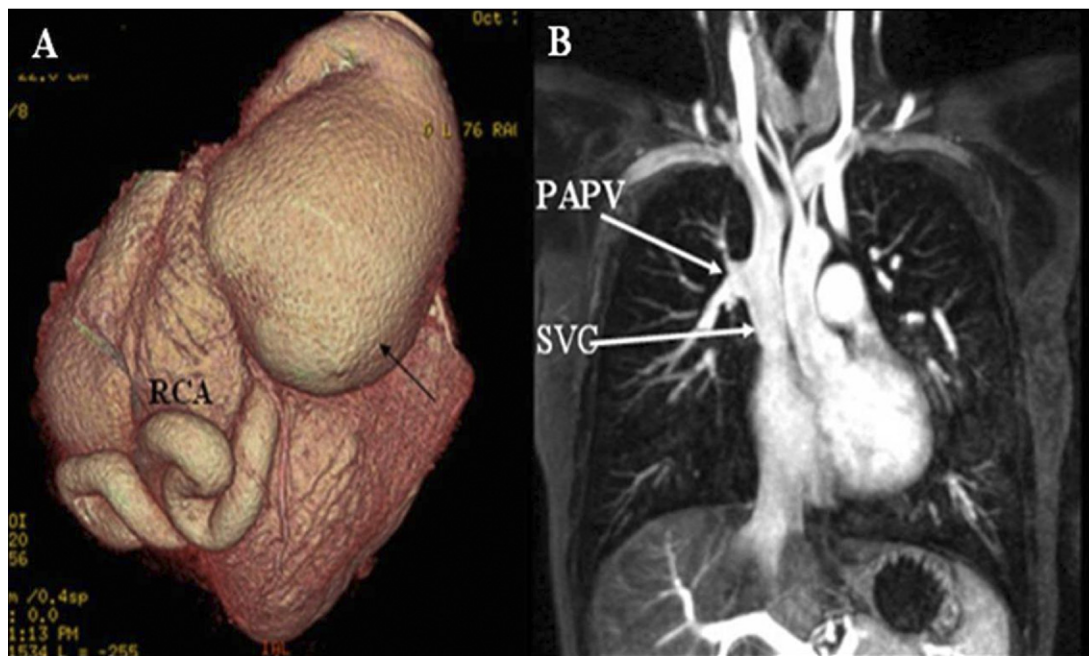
(A) Cardiac CT scan with 3D reconstruction showing giant right coronary artery aneurysm (*black arrow*) in the setting of congenital right coronary artery-to-coronary sinus fistula. (B) Cardiac MRI showing partial anomalous pulmonary venous connection of the right upper pulmonary vein to the superior vena cava. In A or B, the tricuspid valve annulus is usually dilated secondary to right ventricular enlargement and volume overload. RCA, right coronary artery; PAPV, partial anomalous pulmonary vein; SVCL, superior vena cava. (Reprinted with permission of the Mayo Foundation for Medical Education and Research.)
